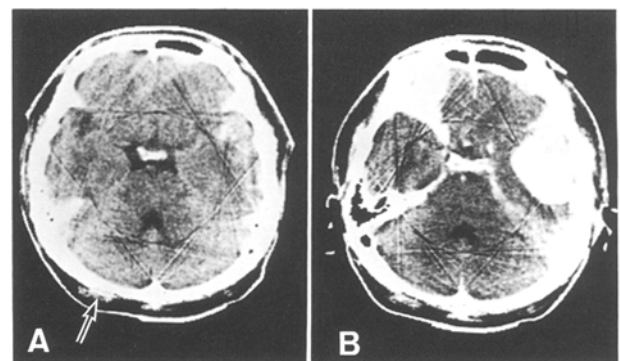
Typical case of rapidly growing TIH (Case No. 26). A) CT taken about 30 minutes after the motorbike accident shows the small haemorrhagic lesion (salt and pepper appearance) in left temporal lobe. It also shows the scalp haematoma in right occipital region (arrow). B) CT taken about 2 hours after the accident shows large TIH
